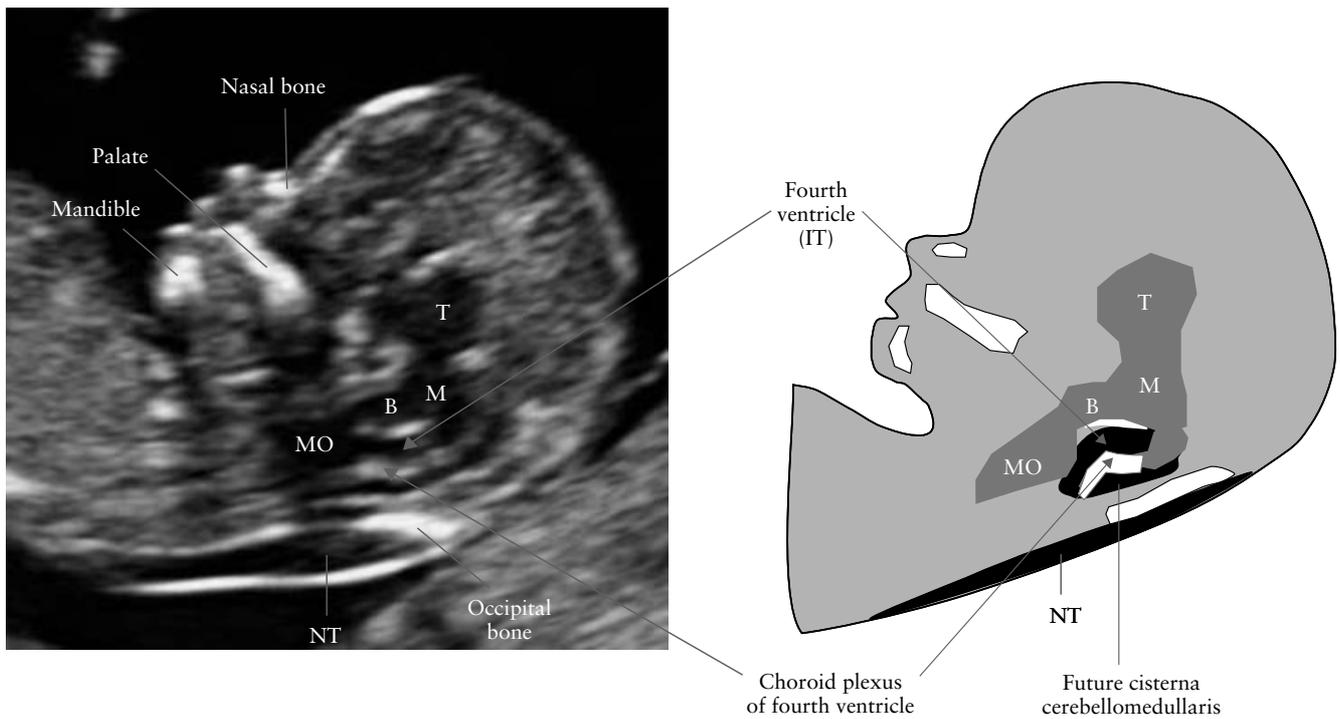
Ultrasound image in the mid-sagittal plane of the fetal face showing the nasal bone, palate, mandible, nuchal translucency (NT), thalamus (T), midbrain (M), brain stem (B) and medulla oblongata (MO). The fourth ventricle presents as an intracranial translucency (IT) between the brain stem and the choroid plexus.
